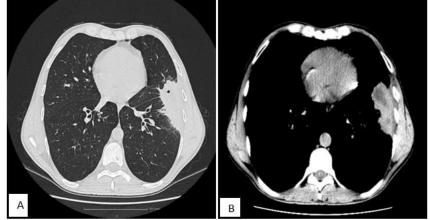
Chest computed tomography. Patient 69 years old. A - axial section in the window of visualization of the pulmonary parenchyma: condensation process at the anterior segment, left inferior lobe, with micro-aeration; B - axial section in the medastinal window: pneumonic process abscessed with central hypodense areas of necrosis.
